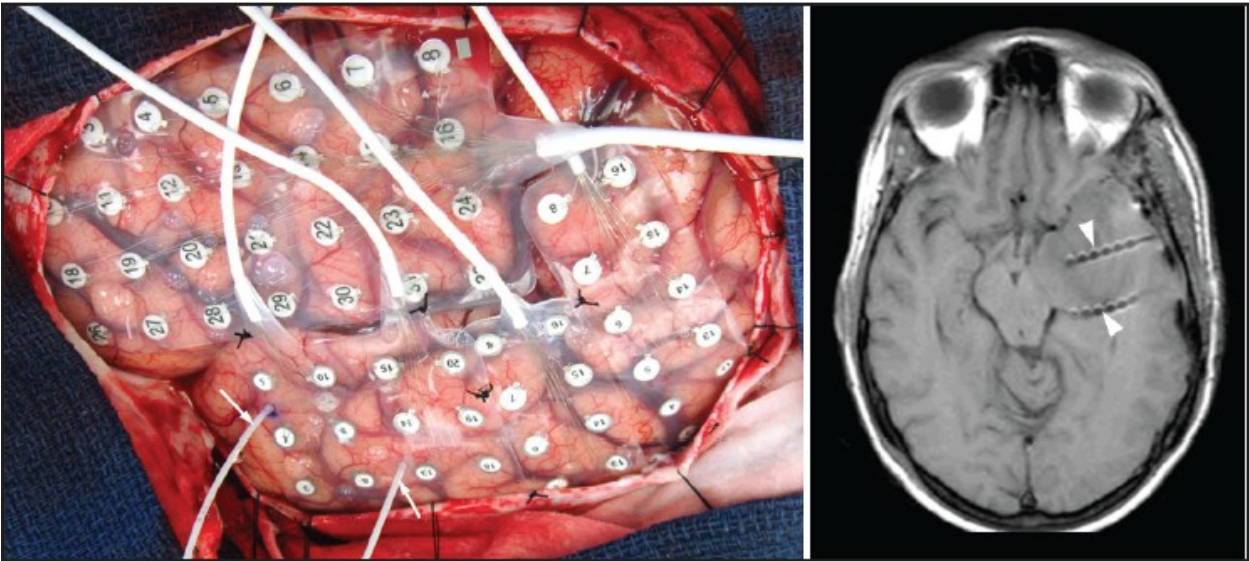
Placement of Grids and Depth Electrodes (Right: CT Scan)
